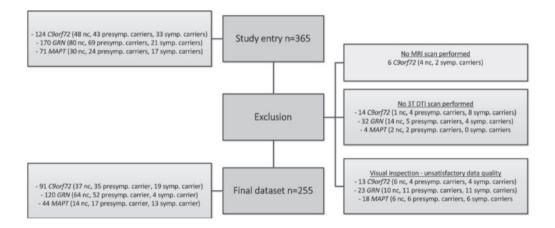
Overview of participant in- and exclusion. 365 subjects were eligible for study participation. Six subjects did not undergo MRI scanning, and were therefore excluded. Only 3T scans were considered, therefore 1.5T (n=34) scans were first excluded from further analysis. Visual quality control of the images resulted in exclusion of another 54 images, leading to a final dataset of 255 subjects (115 non-carriers ("nc"), 104 presymptomatic mutation carriers, 36 symptomatic carriers.
